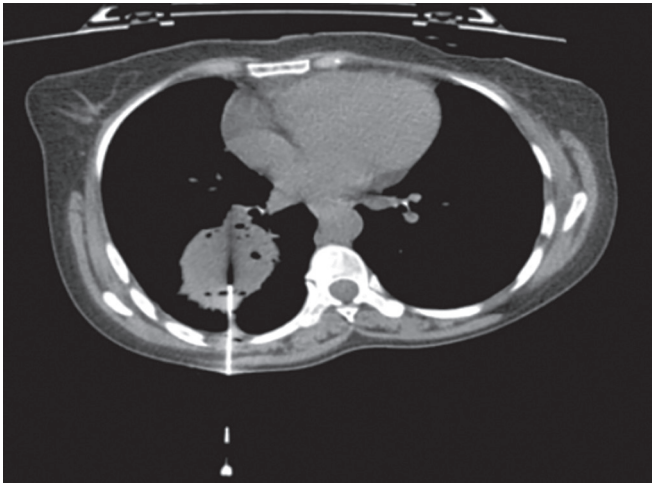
CT guided biopsy being taken from the heterogenous density mass lesion showing “air bubble sign”, case 1
